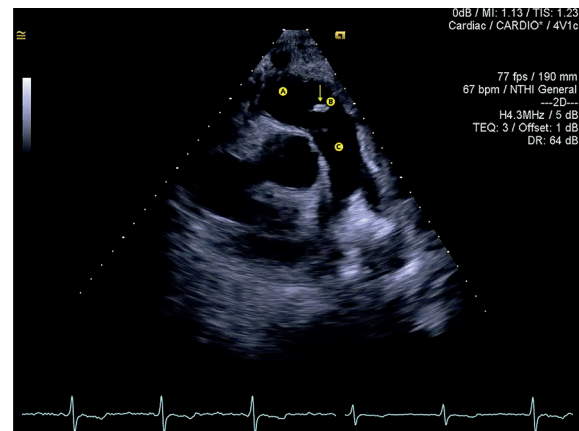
Transthoracic echocardiogram showing the right ventricle (A), pulmonary valve (B) and pulmonary artery (C), with a vegetation (arrow) in the valve.
